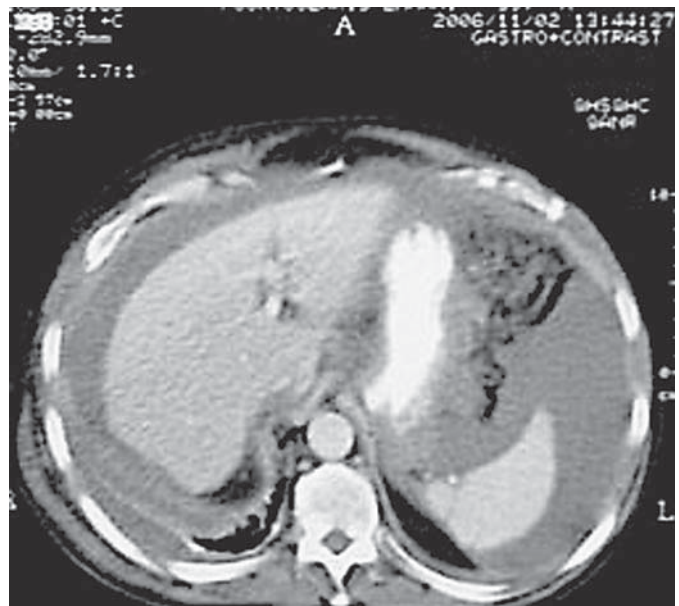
Patient's abdominal computed tomography in November 2006, showing massive ascites.
